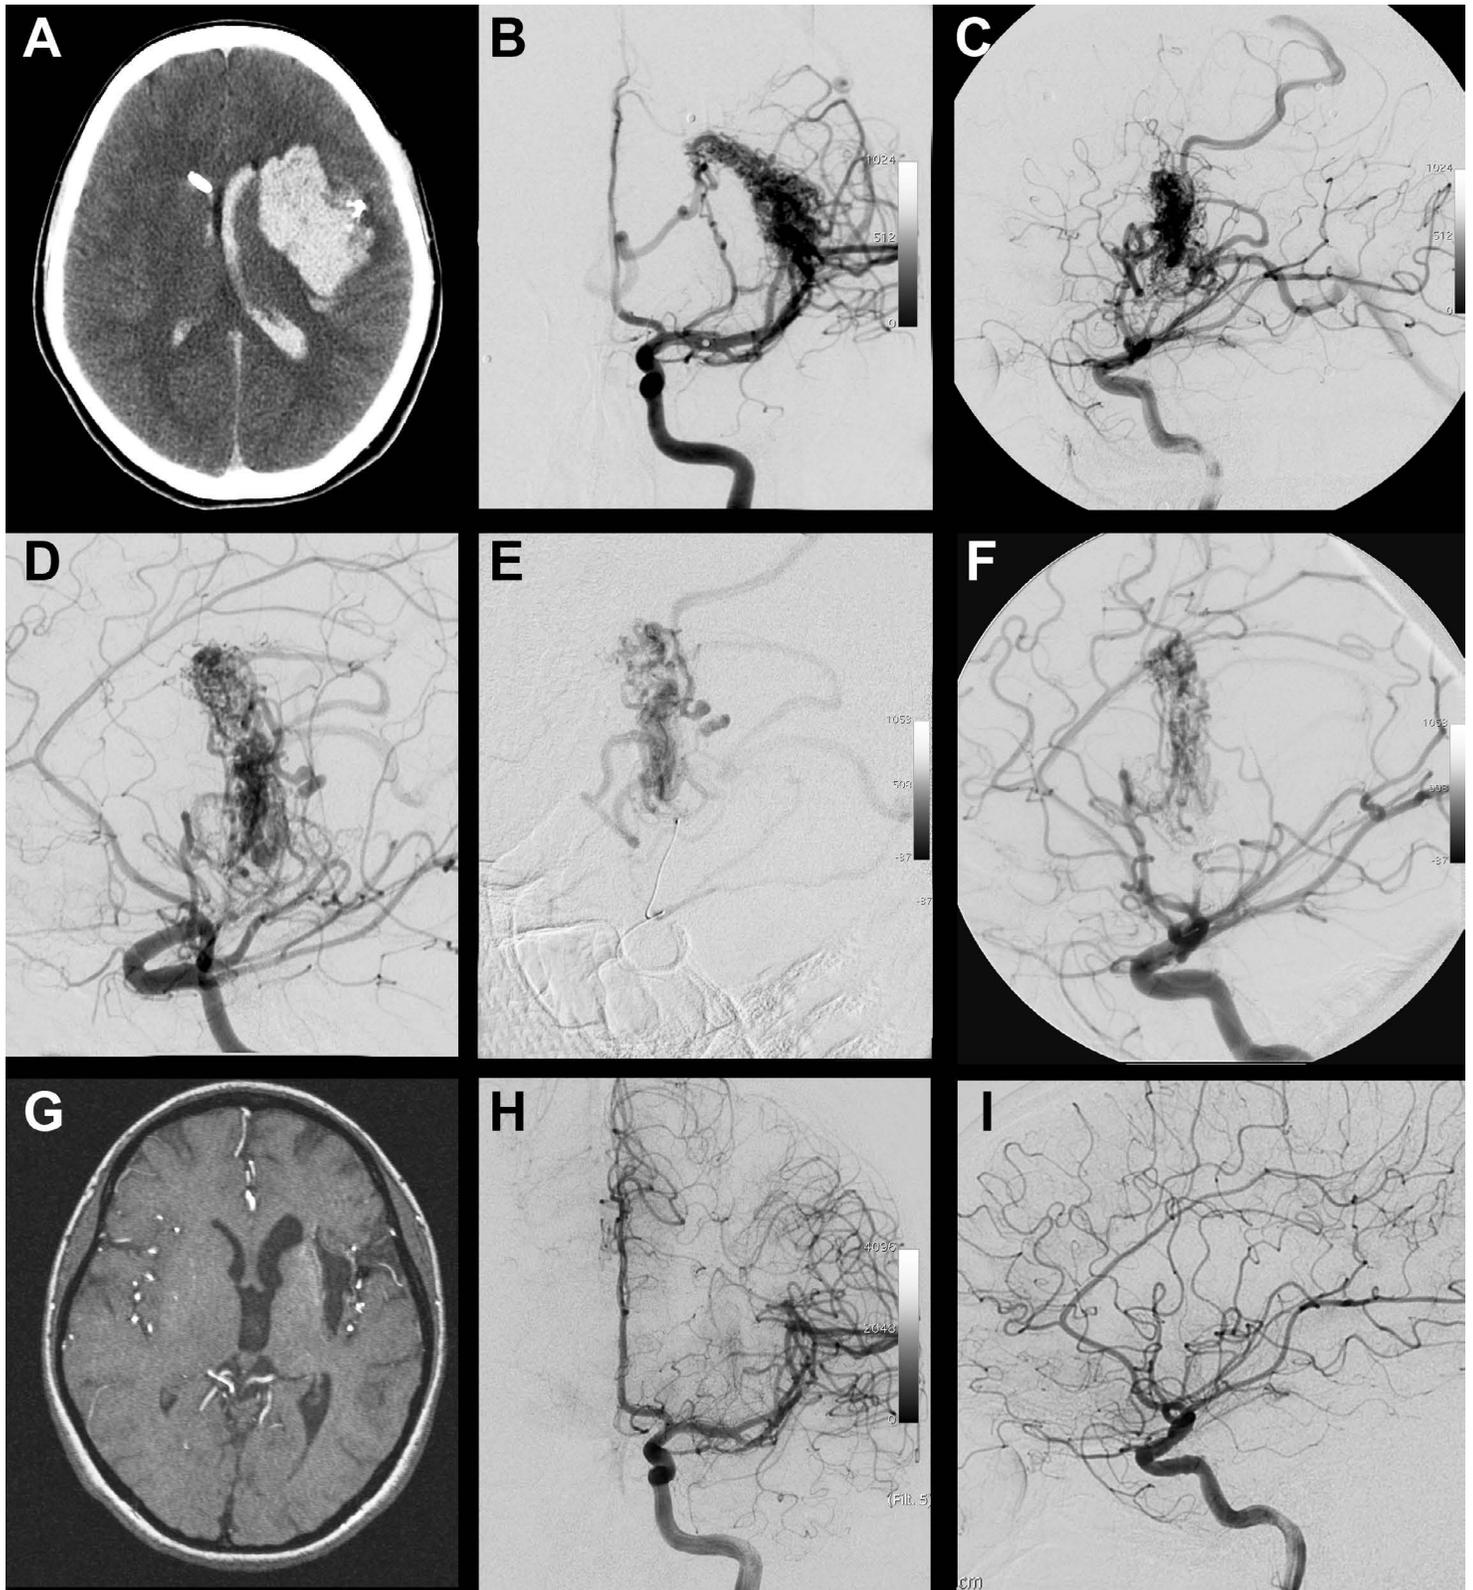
A 24-year-old female who presented with aphasia and hemiplegia. (A) Head CT revealed a left frontal intracerebral hemorrhage with intraventricular hemorrhage. (B, C) Diagnostic cerebral angiography revealed a Spetzler-Martin Grade IV left frontal arteriovenous malformation (AVM). (D-F) A perinidal aneurysm was identified and embolized with n-butyl cyanoacrylate (n-BCA). (G) At 2.5 years after radiosurgery, an MRI reveals no AVM. (H, I) Diagnostic cerebral angiography 3 years after radiosurgery shows no evidence of residual AVM.
